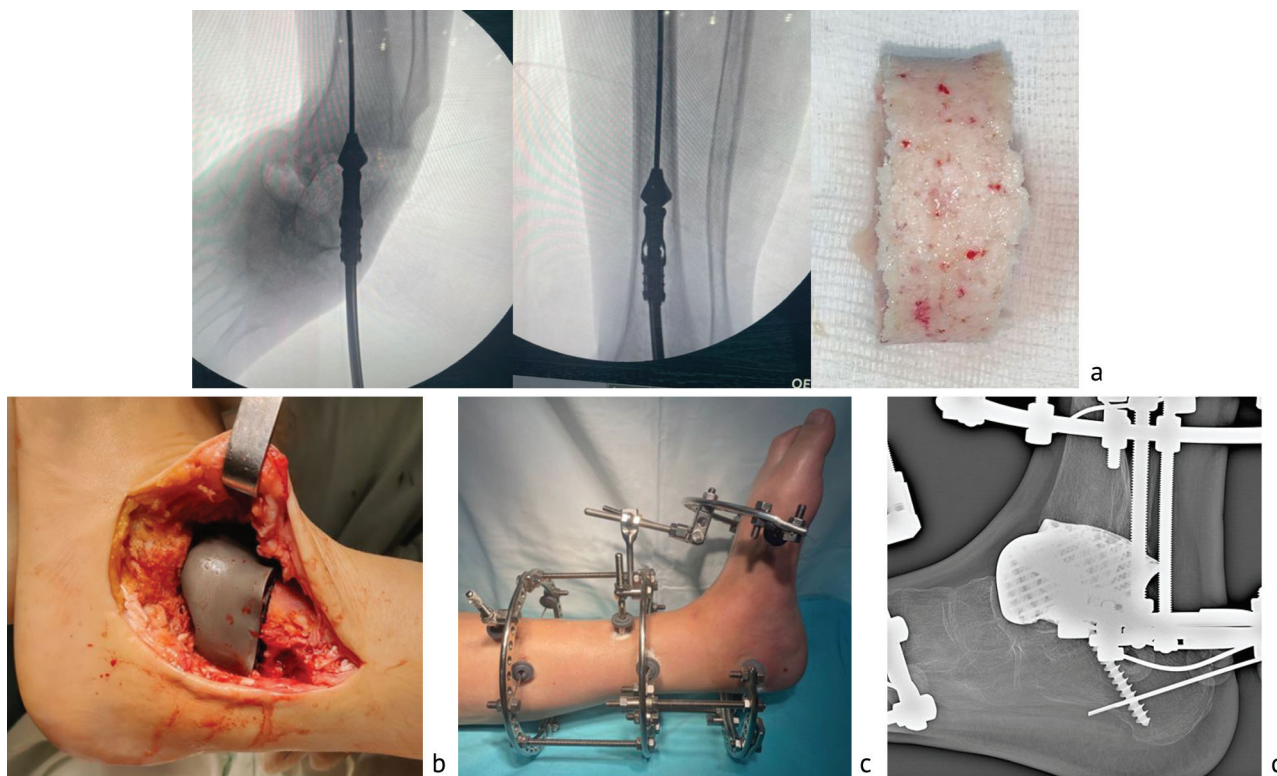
Stages of surgical intervention: using the RIA system, an autograft was taken from the tibial canal (a); placement of the 3D porous titanium customized implant (b); fixation with the Ilizarov apparatus, the final appearance of the foot and ankle joint after surgery (c); X-ray of the foot and ankle joint after surgery (d)
